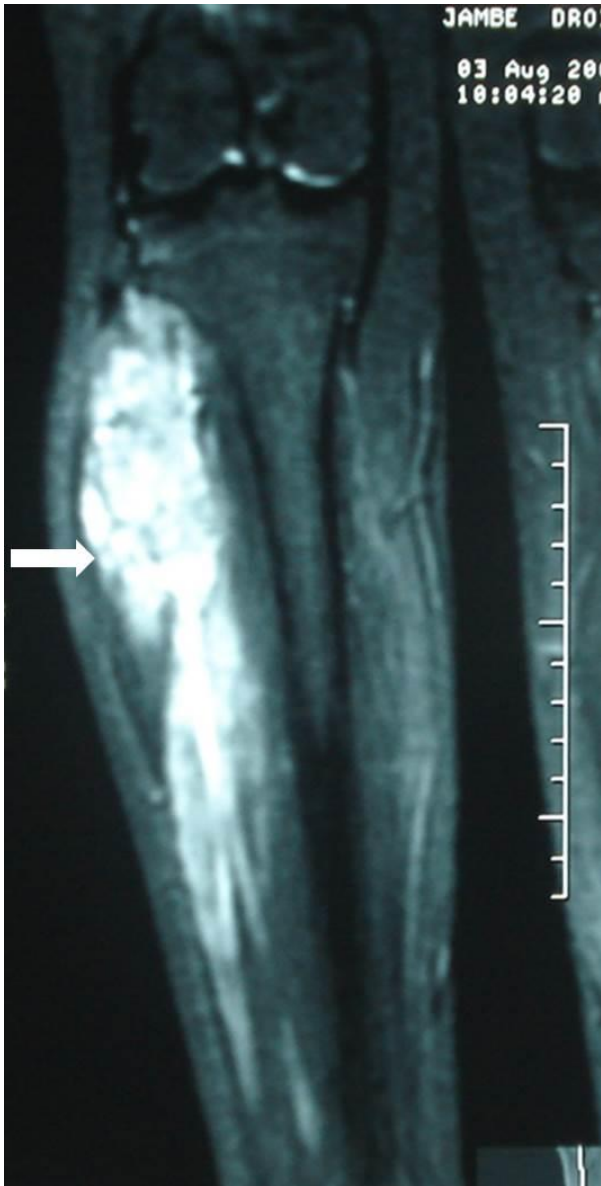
T2-weighted frontal MRI image showing a heterogeneous and hyper intense tumoral process occupying the upper third of the right leg.
